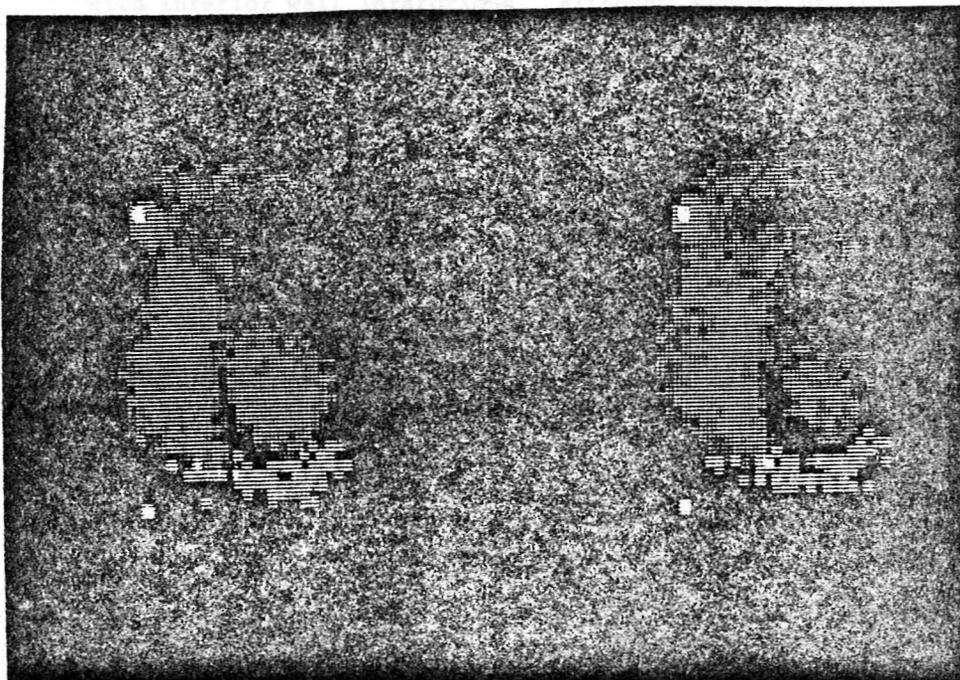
Simultaneous gated blood pool and technetium pyrophosphate scintigrams in diastole (left) and systole (right) of a patient with an inferior left and right ventricular infarctions. (from Corbett, et al⁶³)
